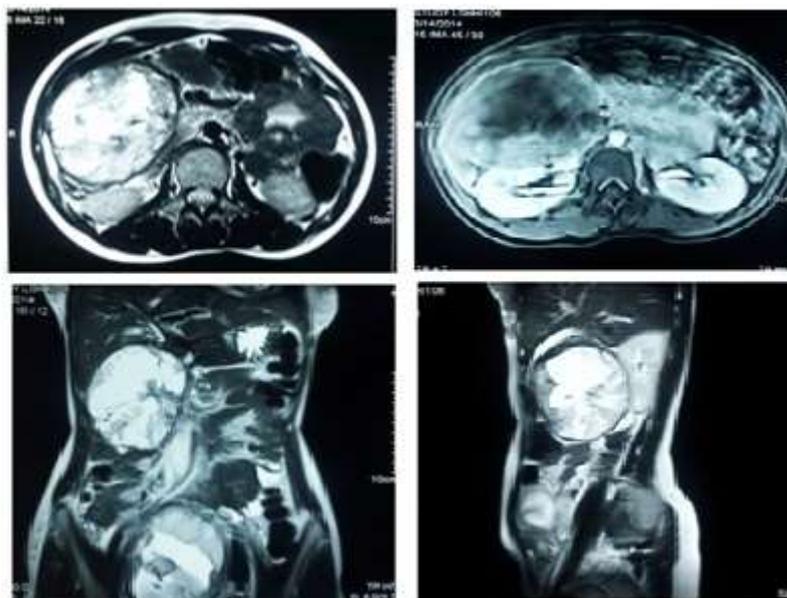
Contrast MRI of abdomen
